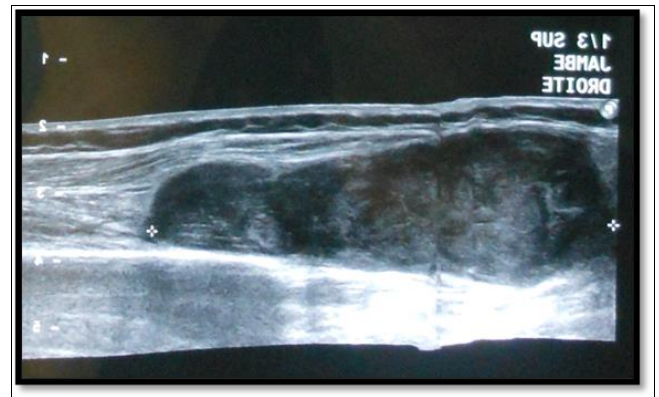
Sonography objectified a homogenous hypoechoic hypovascular mass of the external aspect of the leg, in favour of a nerve tumour.
